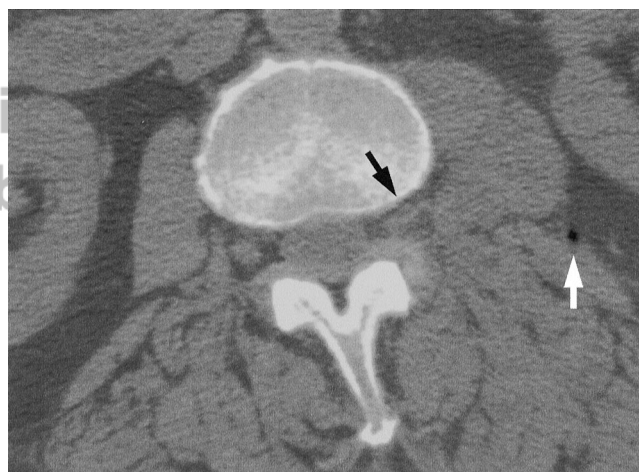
Lumbar spine axial computed tomography scans at L2-L3 foramen level at the onset of high fever. The left iliopsoas muscle was swollen with an inappropriate collection of gas (white arrow). The left L2 dorsal root ganglion was swollen and a margin between the ganglion and epidural fat was blurred (black arrow).
